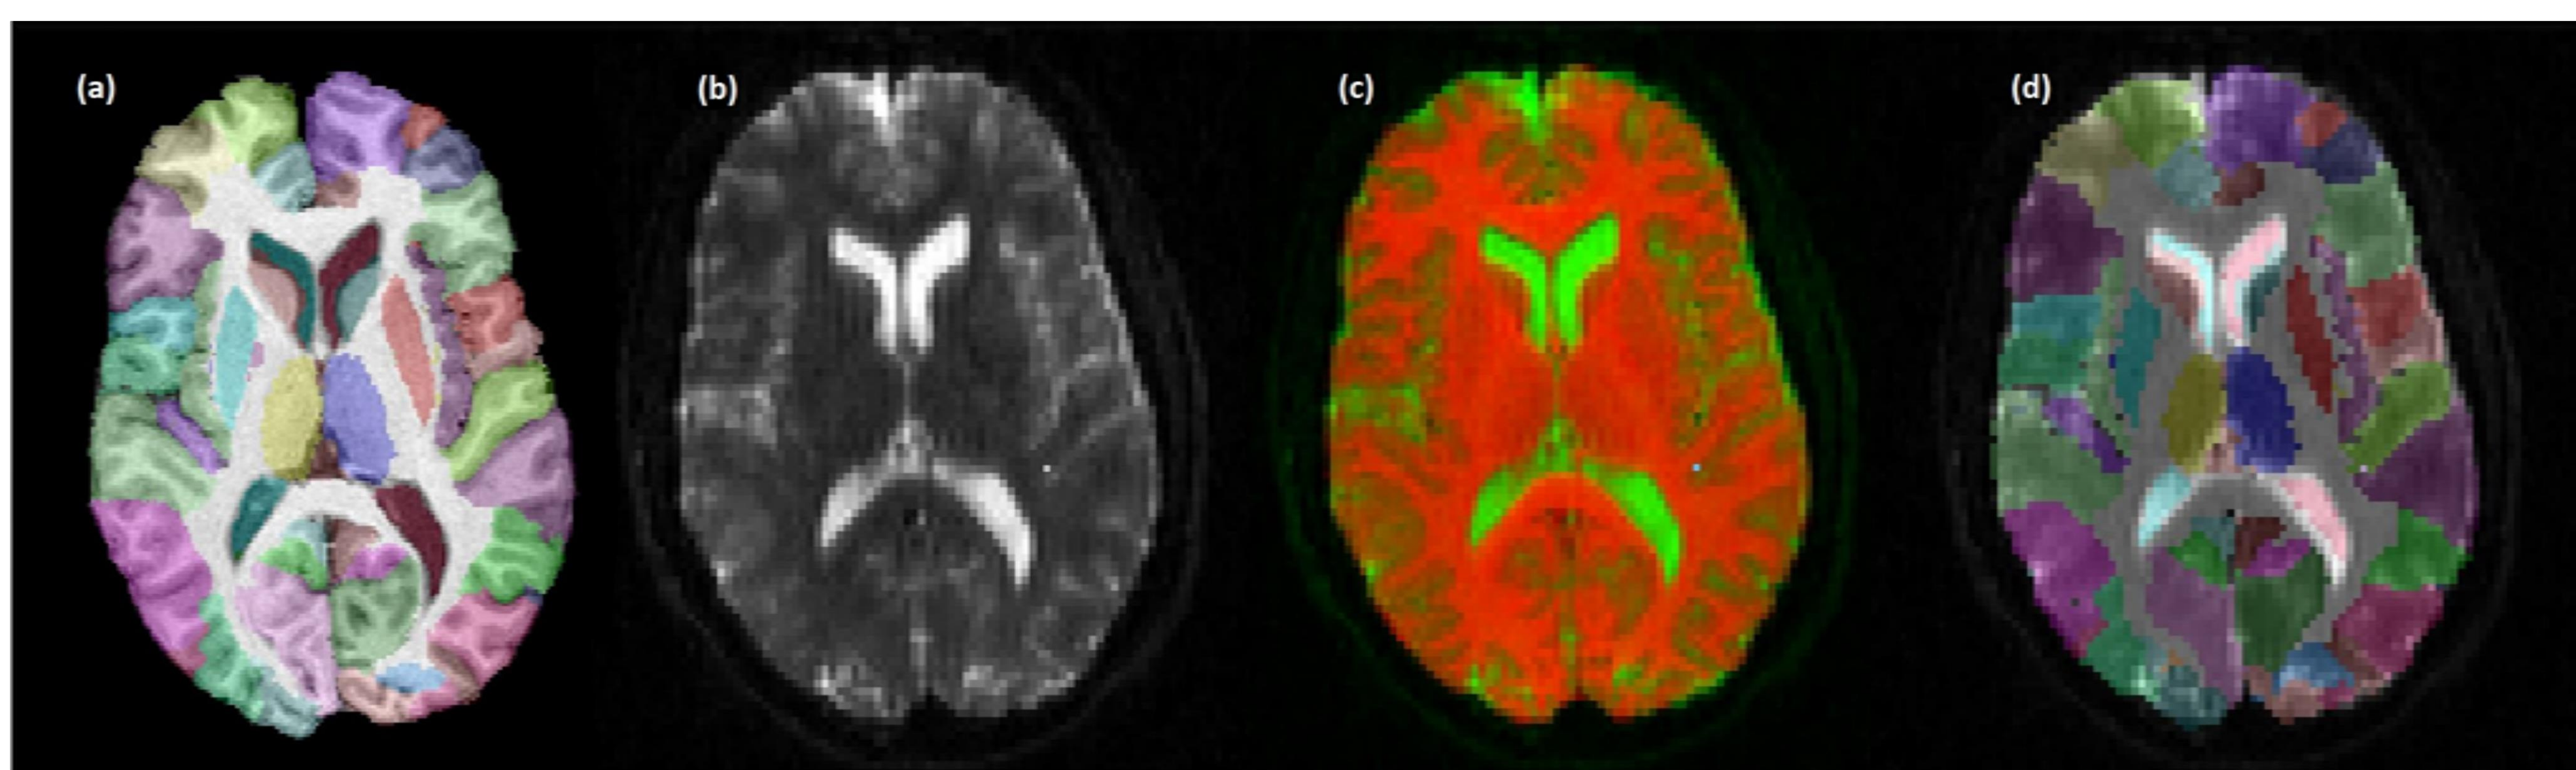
(a) Labeled ROIs displayed on skull-stripped T1-weighted image for one subject. (b) Fieldmap corrected b=0 s/mm² image from diffusion data for the same subject. (c) Overlay of corrected b=0 s/mm² image (in green) and skull-stripped T1-weighted image (in red). (d) Labeled ROIs displayed on corrected b=0 s/mm² image.
